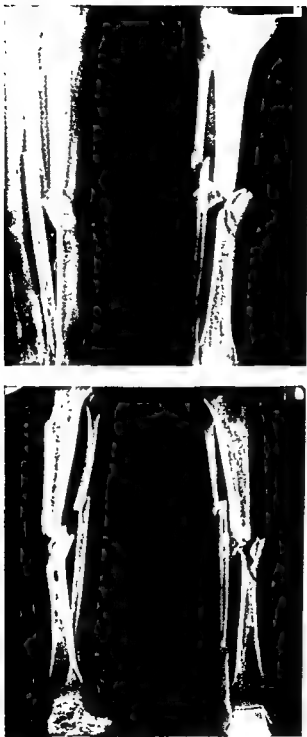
Above, compound comminuted fracture of the leg; below, roentgenogram made after the development of infection.
